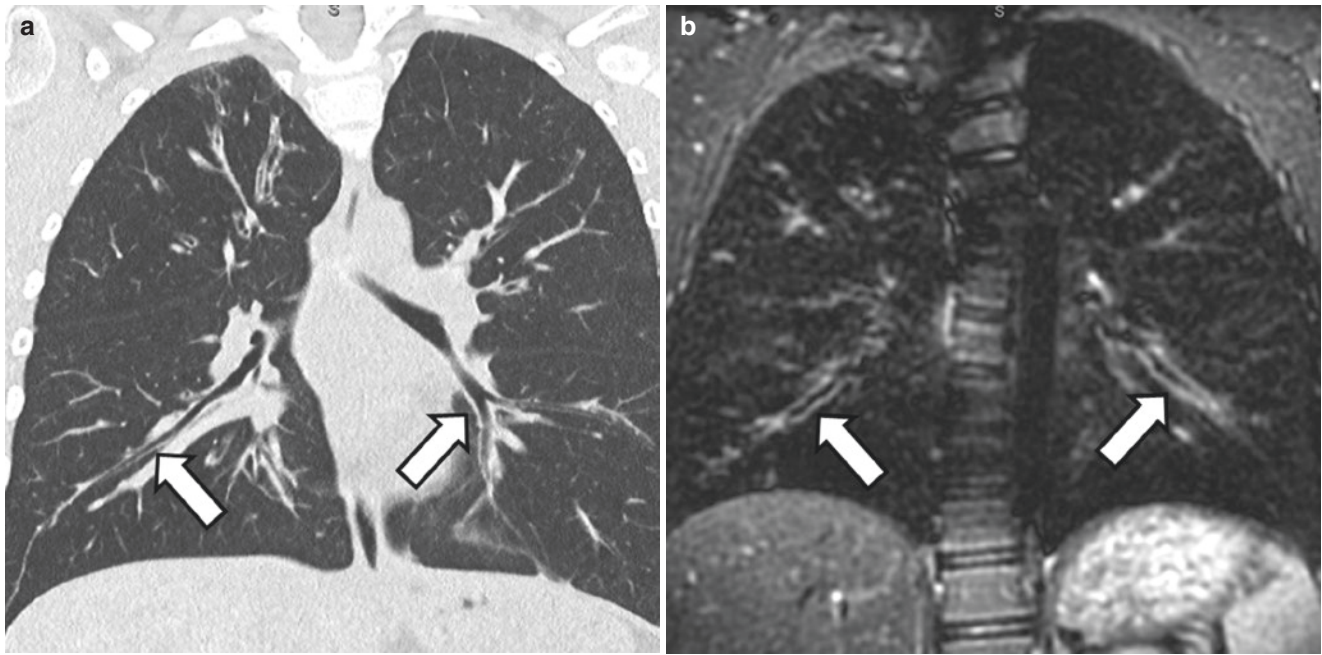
A 13-year-old boy with cystic fibrosis. (a) Coronal non-enhanced lung window setting CT image shows bronchiectasis and bronchial wall thickening (arrows) in both lower lobes. (b) Coronal
